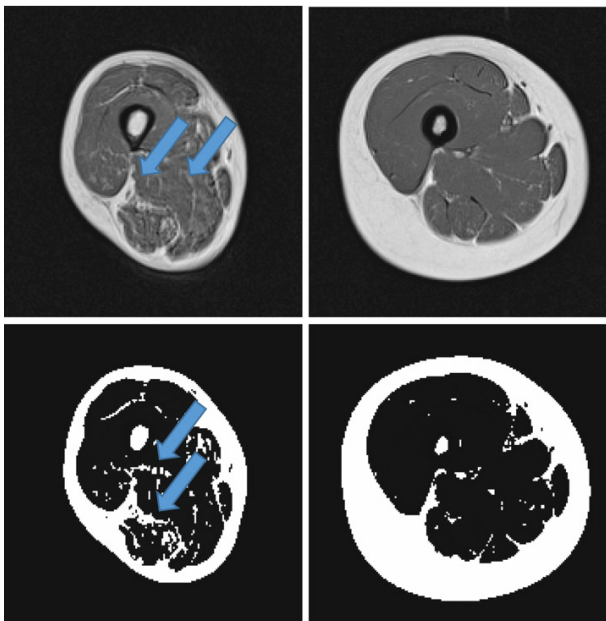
Magnetic resonance images showing the thigh muscles, from women aged 71 years (left upper and lower subfigures) and 21 years (right upper and lower subfigures) (Yoshiko et al., 2017). Increased amount of intramuscular fat is observed on two right figures.
